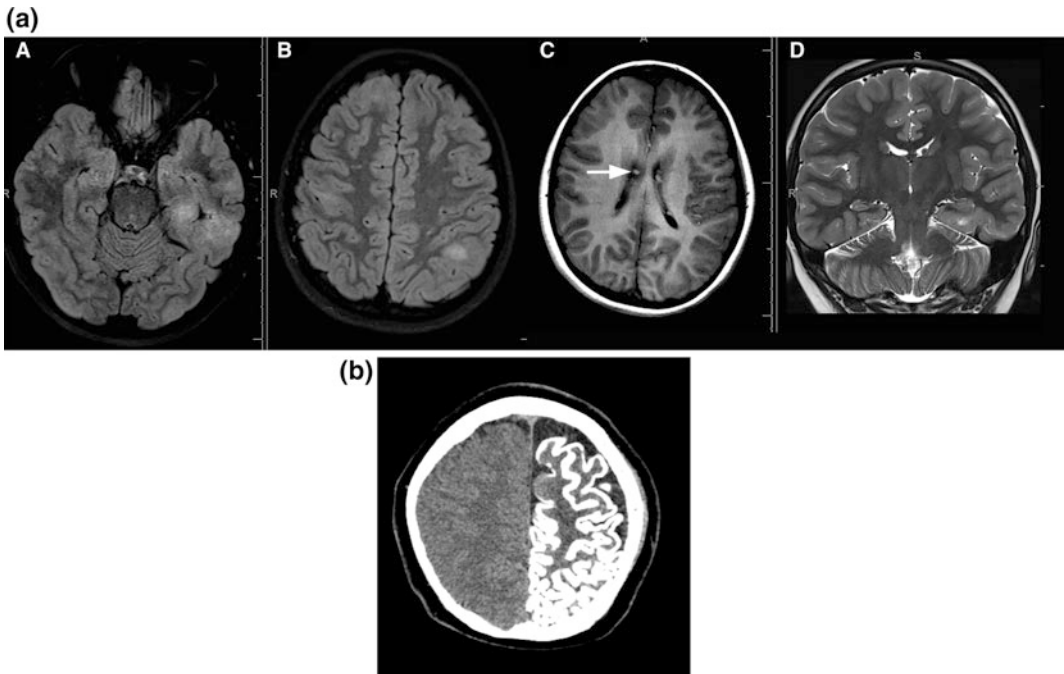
Axial FLAIR (a, b) demonstrates focal T2 hyperintense masses in the cortex and subcortical white matter of the basal left temporal lobe and left inferior parietal lobule consistent with tubers. Axial pre-contrast T1 and coronal T2-weighted MRI demonstrate multiple ependymal nodules along the bilateral caudo-thalamic grooves. These lesions demonstrate subtle T1 hyperintensity (arrow) attributed to calcification that can be seen on CT (not shown). Video EEG suggested the adjacent
